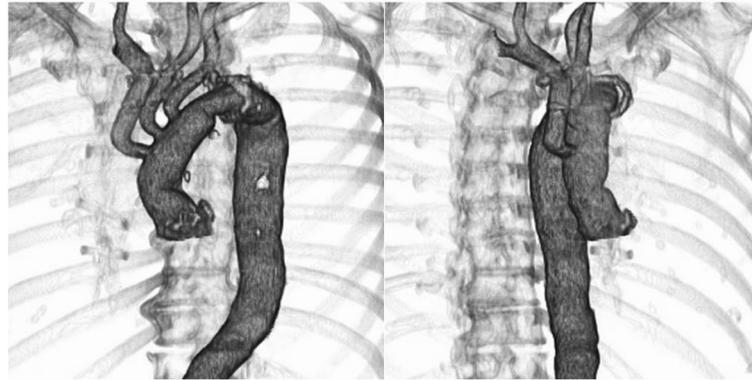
A postoperative computed tomography scan showed patent coronary arteries and no leakage at the anastomotic site.
